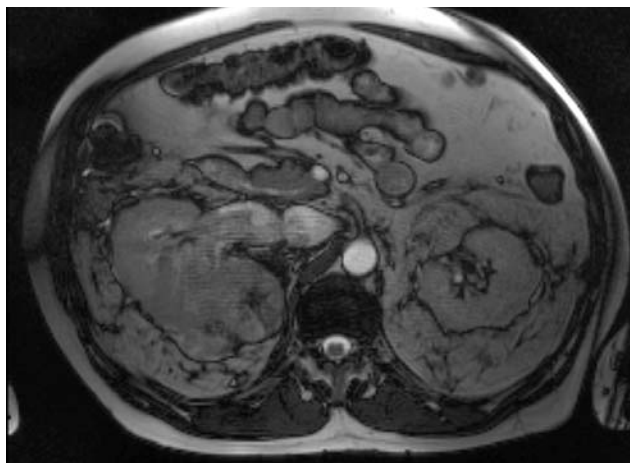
MRI images of a level IV disease
